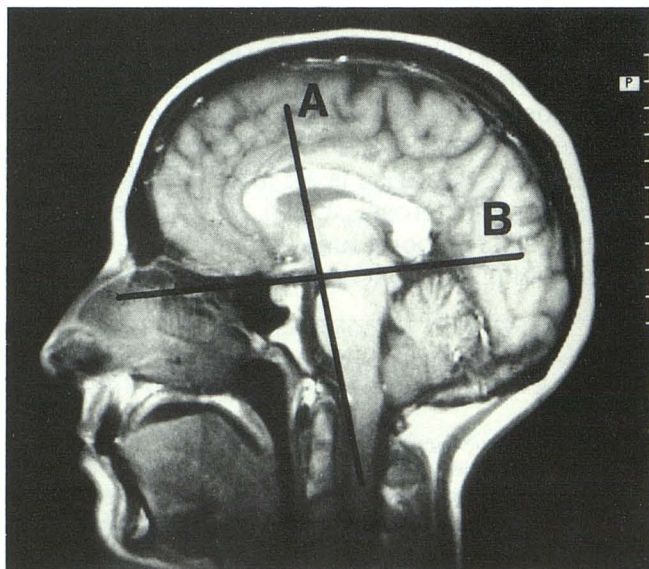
Landmarks for orientation of the central section of the modified imaging axis in the coronal (A) and axial (B) planes are shown in the sagittal scout view. The latter plane is tilted approximately 35° from the standard CT imaging axis. Generally these axes are approximately at right angles to each other.
